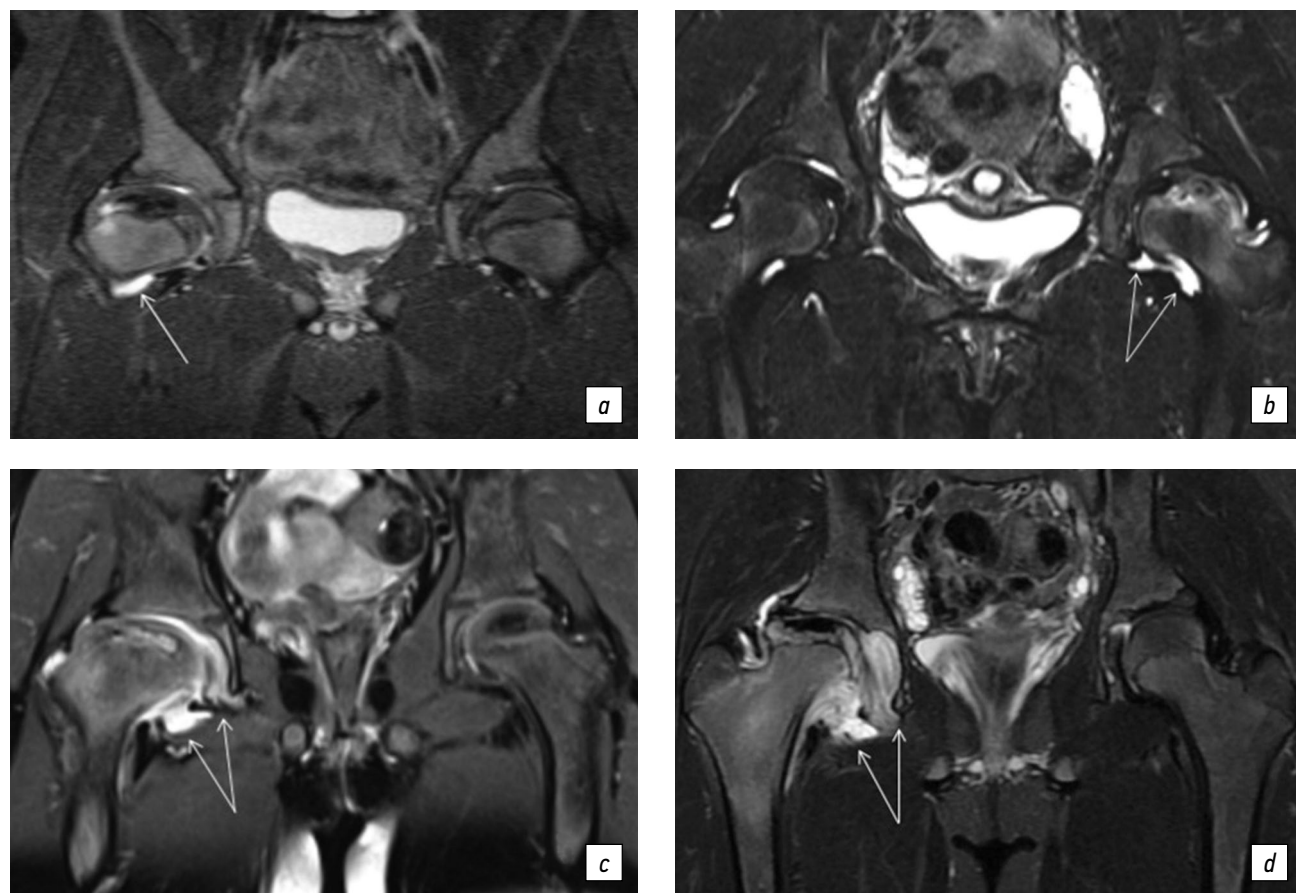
Magnetic resonance imaging: signs of varying severity of synovitis in the hip joint in children with LCPD. STIR mode images show (a) minimal effusion within the joint capsule, (b, c) moderate synovial fluid accumulation stretching the joint capsule with synovial reaction, and (d) significant synovial fluid accumulation stretching the joint capsule with synovial proliferation
